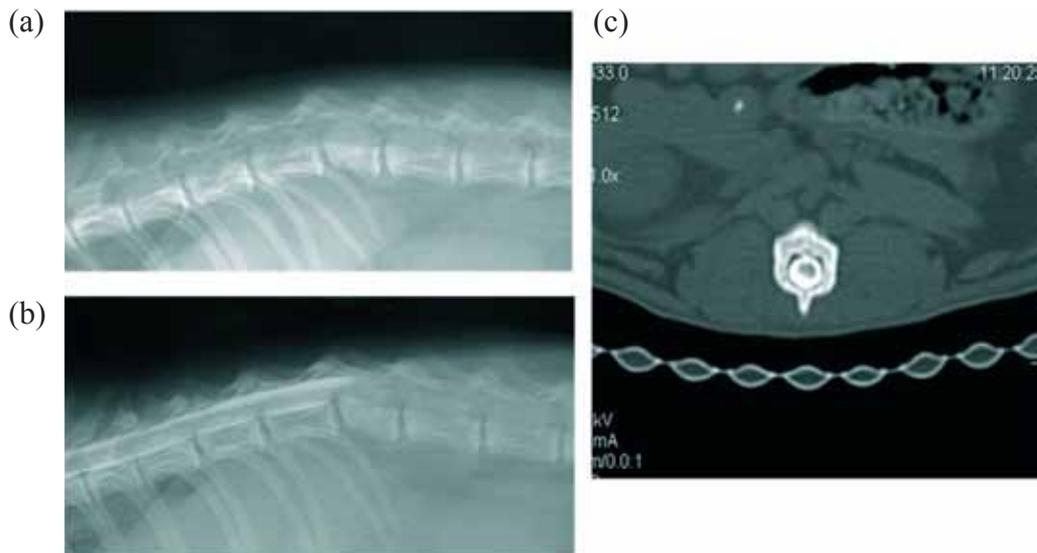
X-ray image, myelography, myelo-CT. X-ray, showed an abnormal size and profile of the L1 vertebral body, consistent with a previous vertebral fracture or malformation (a). Myelography showed an abrupt interruption of the progression of the contrast medium, associated with thickening of the dorsal contrast column in correspondence of the T13–L1 intervertebral space (b). Myelo-CT confirmed the compression of the spinal cord of the T13–L1 and the presence of L1 vertebral body alterations, consistent with a previous fracture or malformation (c)
